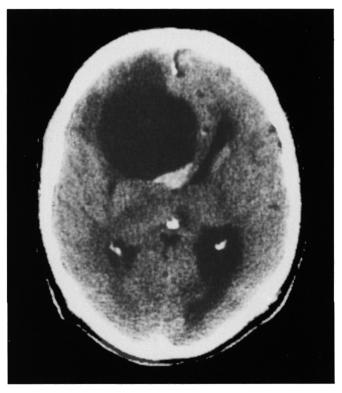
Computerized tomograph (CT) scan of Case 2 showing a large cystic lesion in the right frontal area extending posteriorly with a high density area.
